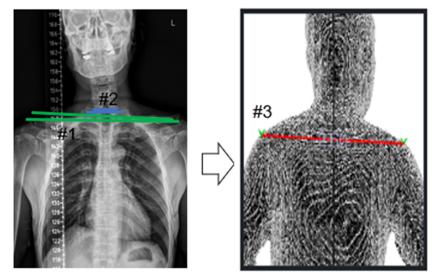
#1. Clavicle angle, #2. T1 coronal tilt on x-ray, #3.Shoulder gradient on 3d scanner
